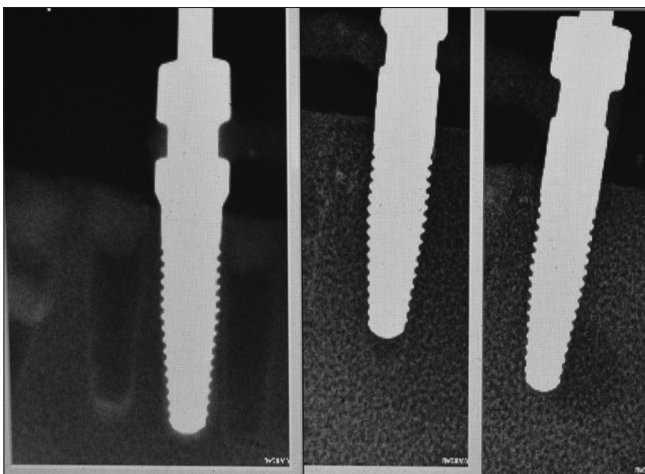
IOPA of the control model. IOPA: Intra Oral Periapical radiographs
